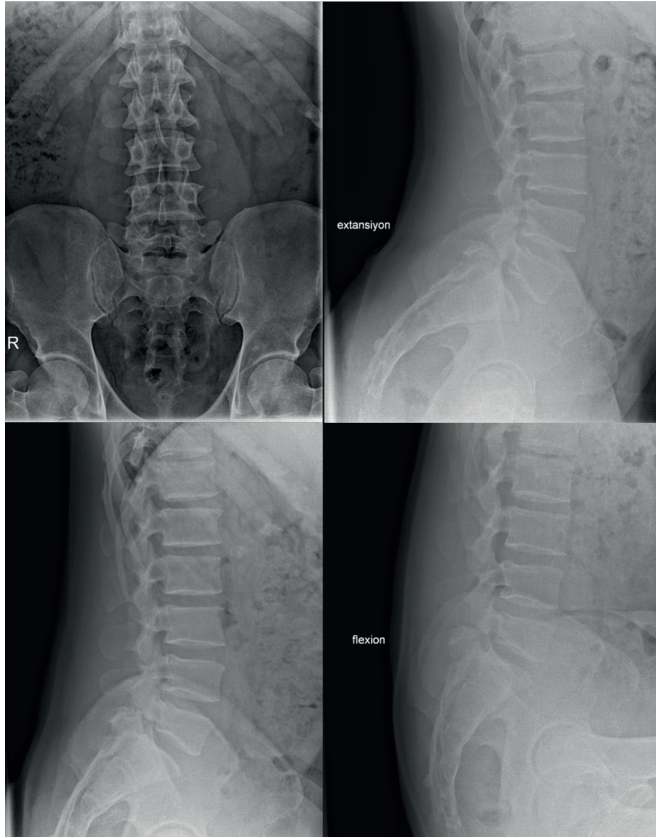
Dynamic lumbar radiographs demonstrating spondylolysis and segmental instability. Anteroposterior and lateral lumbar spine radiographs with flexion and extension views. The dynamic lateral images demonstrate anterior translation of the L5 vertebral body over S1, consistent with isthmic spondylolisthesis associated with pars interarticularis defects. Flexion–extension views are useful for evaluating segmental instability and dynamic vertebral slippage.
